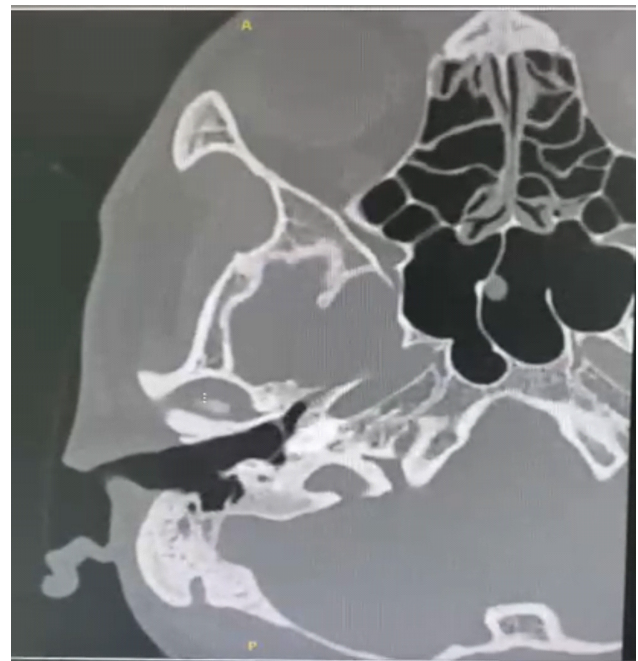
(a): High-resolution computed tomography (HRCT) of temporal bone. Presence of chronic otomastoiditis with post-operative changes and soft tissue densities at the remnant of the right mastoid air cells.
